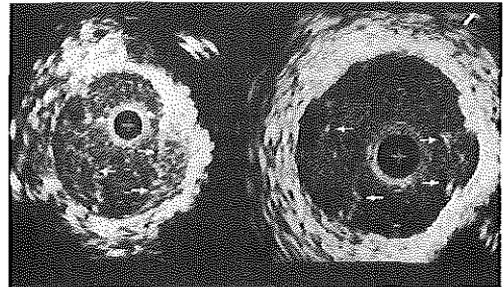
Intravascular ultrasound cross-sections of a venous bypass showing differences between remnants of valve leaflets and an intact valve. Left panel: four remnants of valve leaflets are seen after valve cutting (arrows). Blood appears as a homogeneous echogenic medium in the lumen. Right panel: after valve cutting an intact valve leaflet (left: 3 arrows) and a disrupted valve leaflet (right: 2 arrows) are seen on ultrasound. The stagnant blood behind the intact leaflet causes a more homogeneous echogenic structure than blood flow in the lumen. + = Catheter; calibration = 1 mm.
